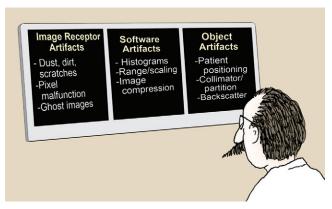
Classification scheme for digital radiographic image artifacts.
